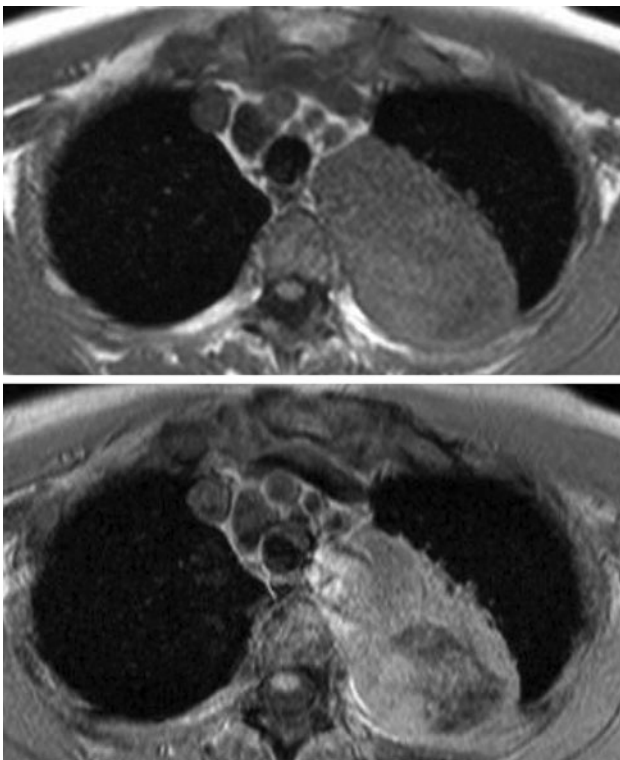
Chest MRI. The tumor shows no apparent invasion of the chest wall or ribs
